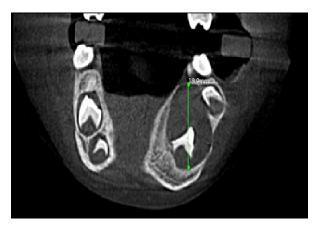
CBCT coronal view shows embedded 33 in the osteolytic lesion and buccally pushed 34 with both buccal and lingual plate expansion and thinning
